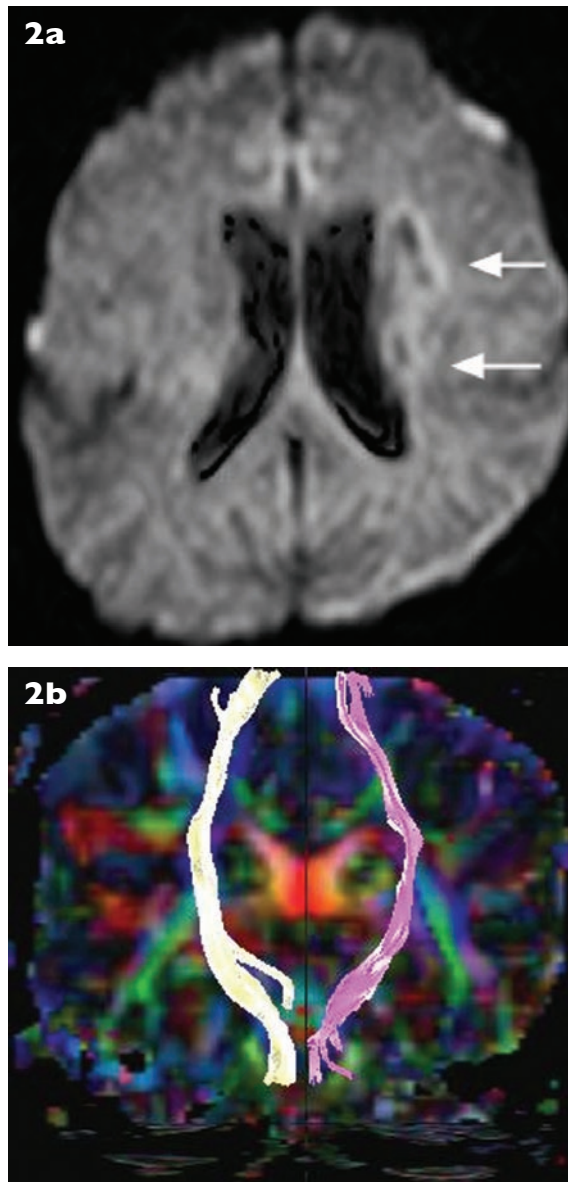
Case 2. (a) DWI shows left cortical and subcortical chronic infarction (arrows). (b) MR tractography shows the full extent of the left corticospinal tract, which shows decrease in calibre compared to the right side, due to wallerian degeneration.
